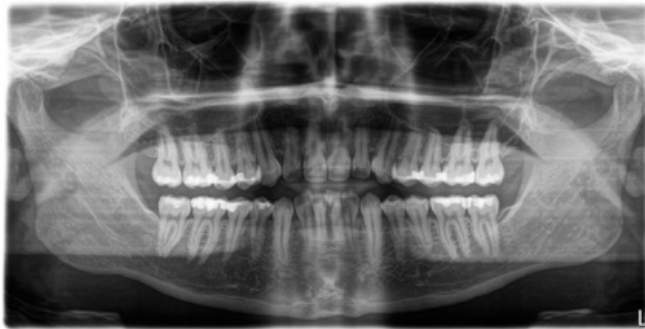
Panoramic X-ray (Wikipedia, 2021)
